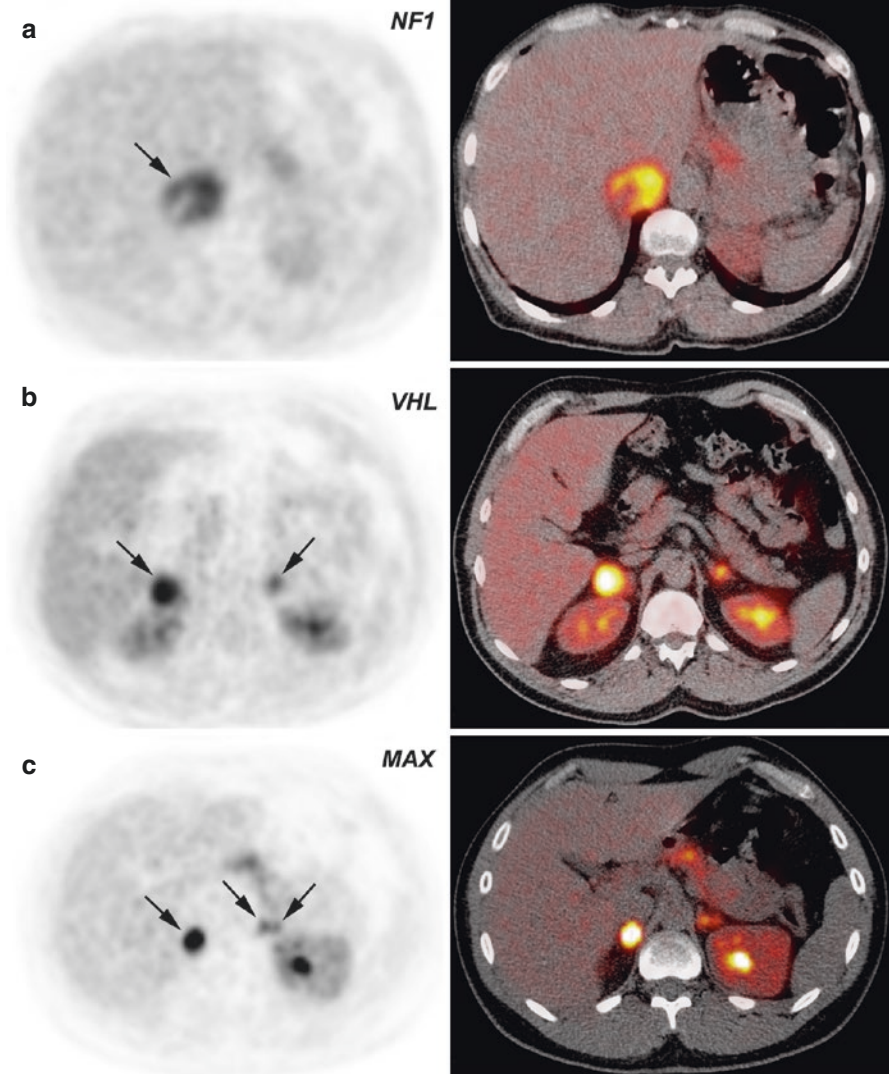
^{18}F -FDOPA PET/CT findings in hereditary PHEOs. (a, b) *NF1*-related right PHEO. (c, d) Bilateral *VHL*-related PHEO. (c, d) Bilateral *MAX*-related PHEO (note the presence of two foci within the left adrenal gland)
